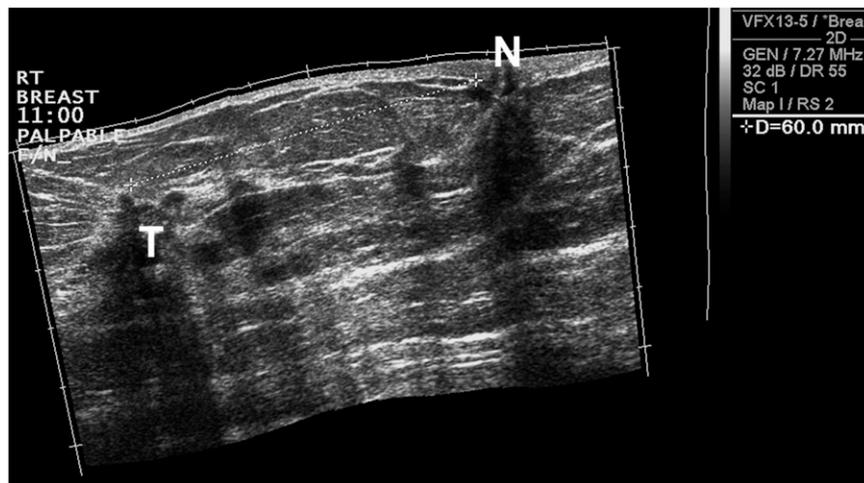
Extended-field-of-view sonogram along the 11 o'clock radius passing through the nipple and the tumor. The distance from the tumor to the nipple is 6 cm.
